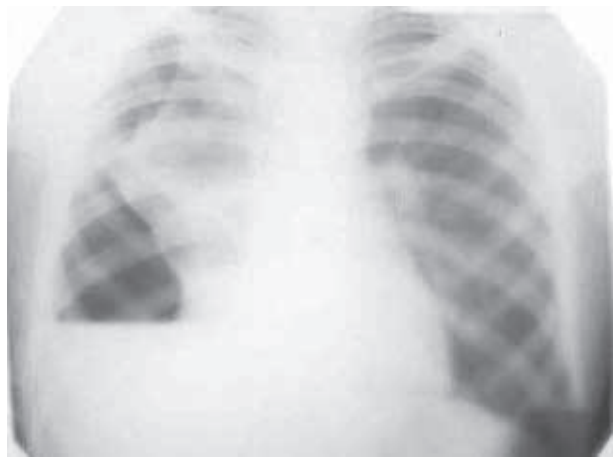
X-ray of hemopneumothorax
